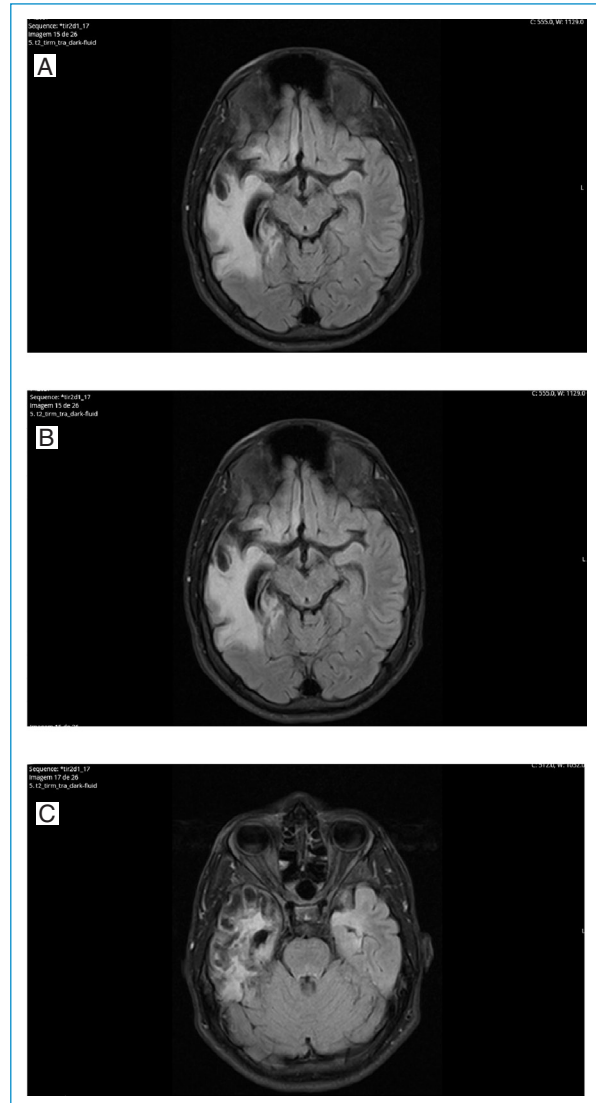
A, B and C: brain MRI images depicting predominant damage on the right side, affecting the right temporal lobe and limbic structures. There is marked atrophy of the right insular cortex, involving the right internal frontobasal region, and the anterior temporal area. There is also involvement of the left insular and periventricular regions, although less pronounced. Significant dilation is noted due to the retraction of the temporal horn of the right ventricle, with particularly relevant encephalomalacia observed in the anterior and inferior temporal areas on the right side.
